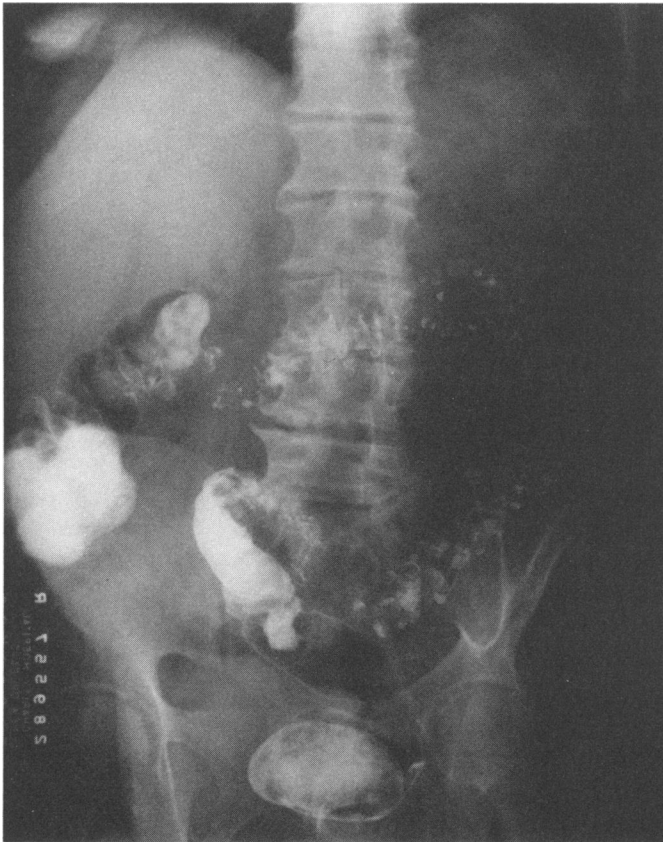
Emergency barium enema X-ray obtained in a 67-year-old patient with exsanguinating colonic bleeding. Diffuse diverticulosis is evident with involvement of the entire colon. There was no evidence of diverticulitis. Emergency subtotal colectomy with side-to-end ileosigmoidostomy was performed. The patient had an uneventful postoperative course and is now well with no rebleeding. He has two formed bowel movements per day.
